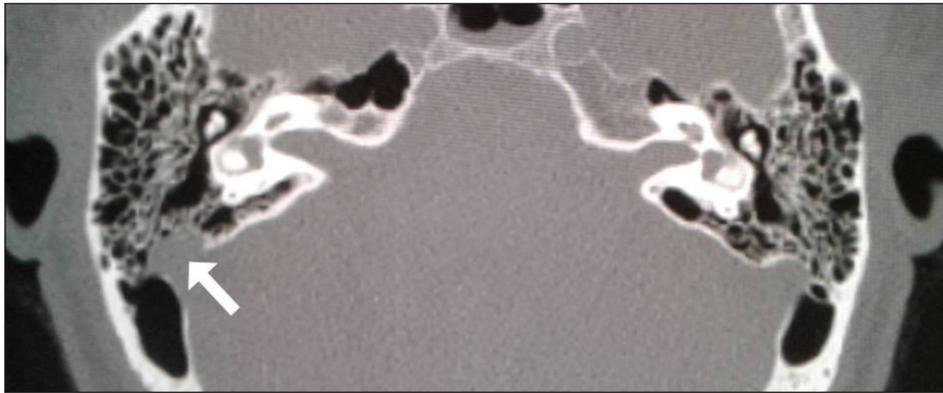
Axial CT image of the temporal bone at the level of the horizontal semicircular canals : absence of the normal thin layer of cortical bone overlying the right sigmoid sinus (white arrow) compared to the left sigmoid sinus
